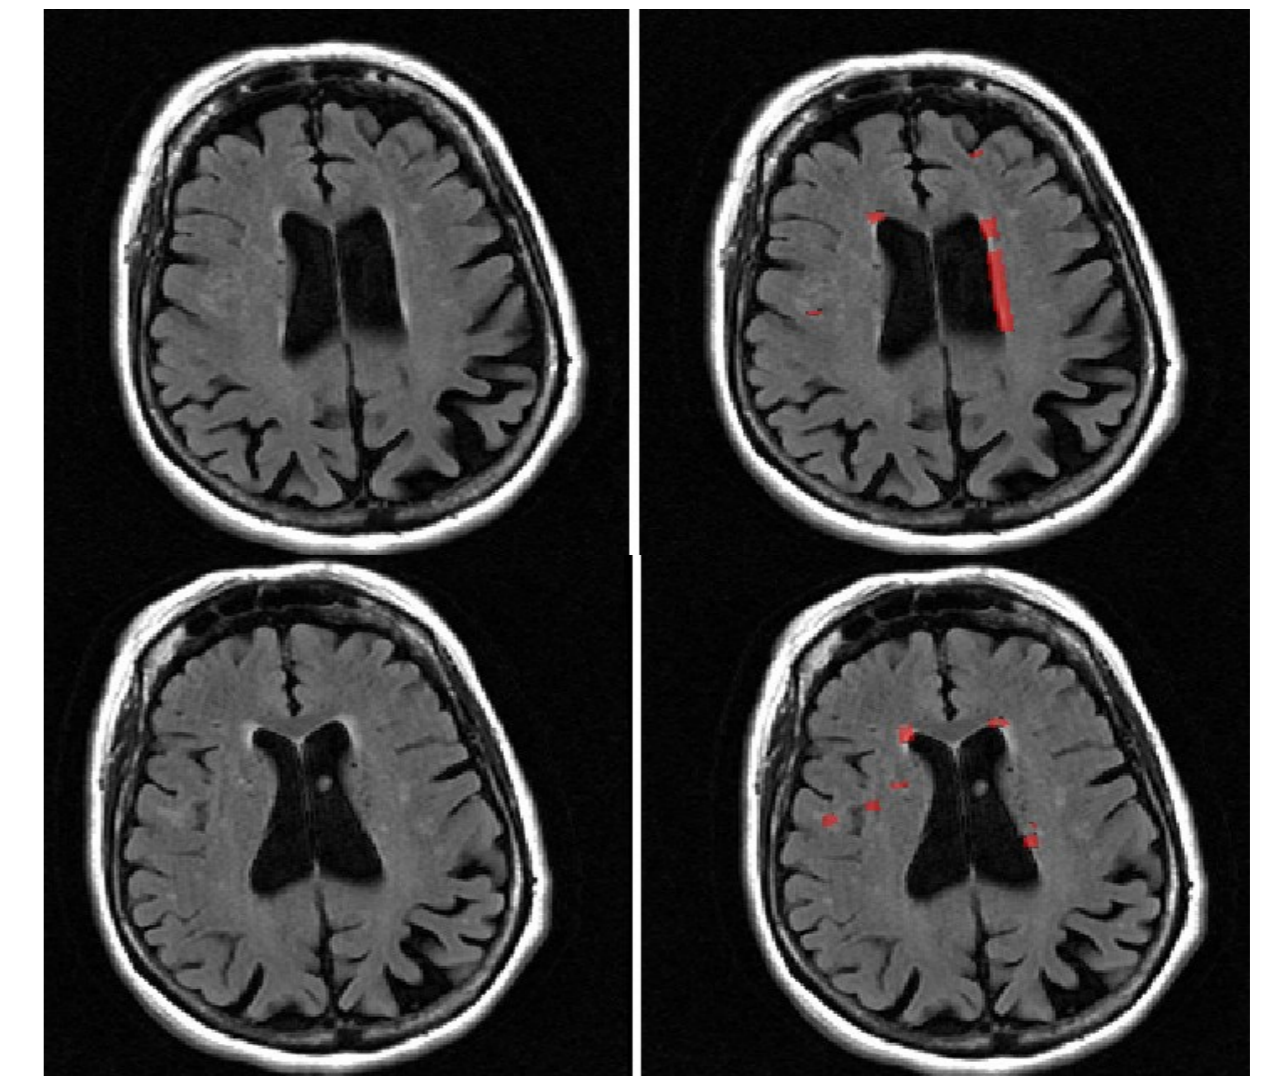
FLAIR MR images (on the left) and the same slice with automated segmented lesions (on the right).
